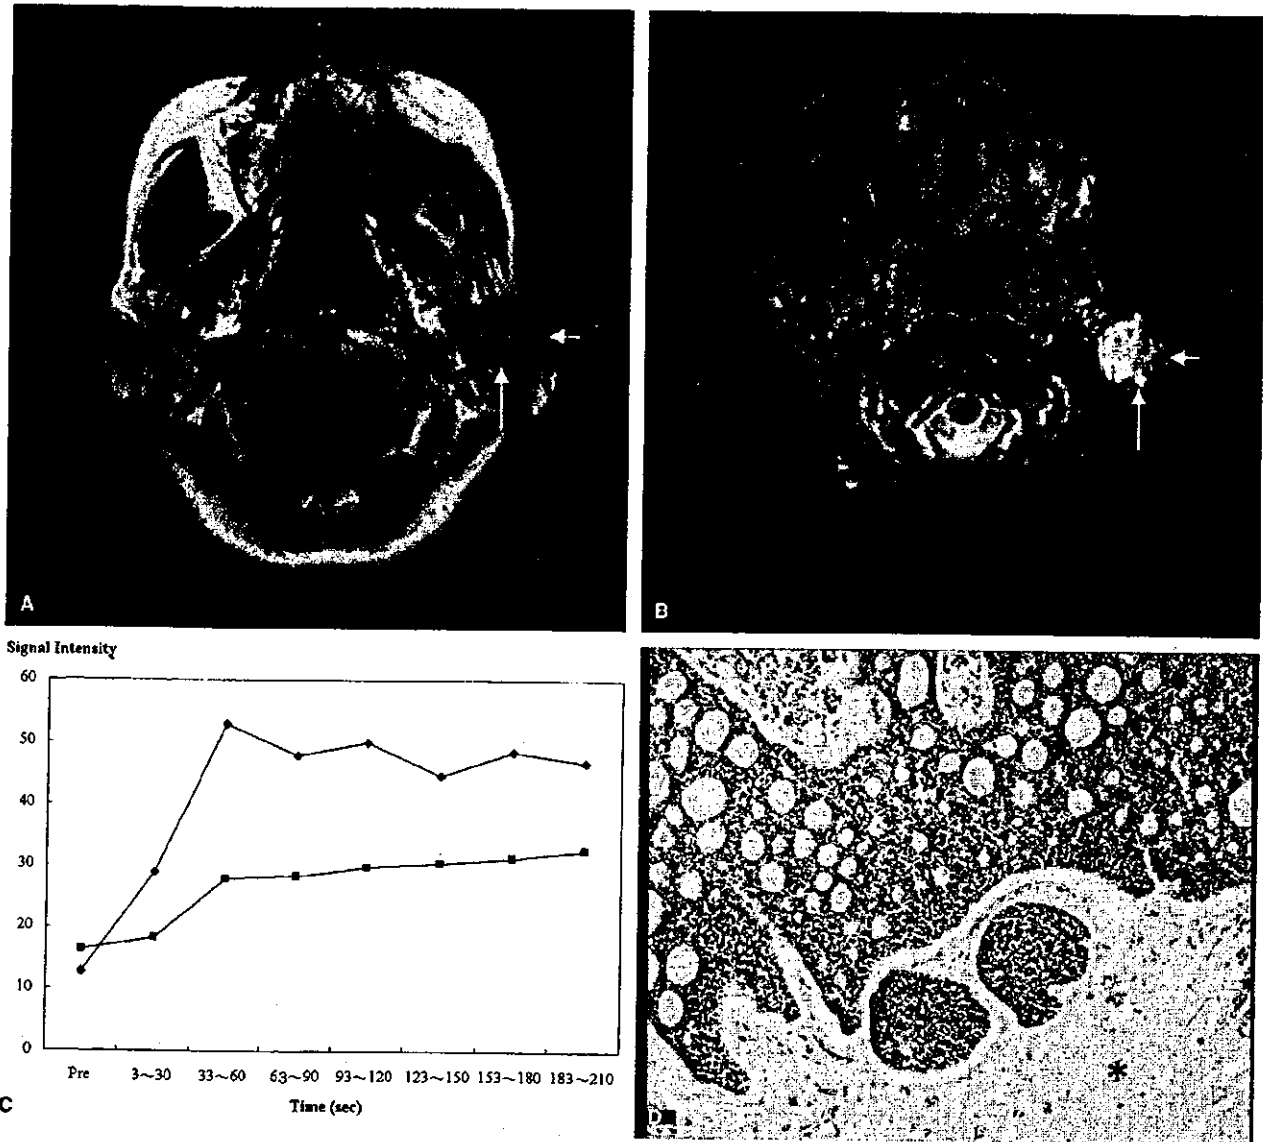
Adenoid cystic carcinoma in the left parotid gland of a 56-year-old woman. A, T1W image [400/9 (TR/TE), axial plane] of the maximal diameter section shows a lobulated tumor of isointensity (arrows). B, STIR (4000/30, axial plane) shows marked high-intensity tumor with ill-defined lateral border (arrows). C, The high-intensity region on STIR image has type D perfusion curve on dynamic MR images. The other region has type B perfusion curve. D, The region with marked high intensity on STIR images and type D perfusion curves on dynamic MR images is myxoid-rich tissue (*). The remaining region has nests of neoplastic epithelial cells containing several small, round, and pseudocystic structures.
